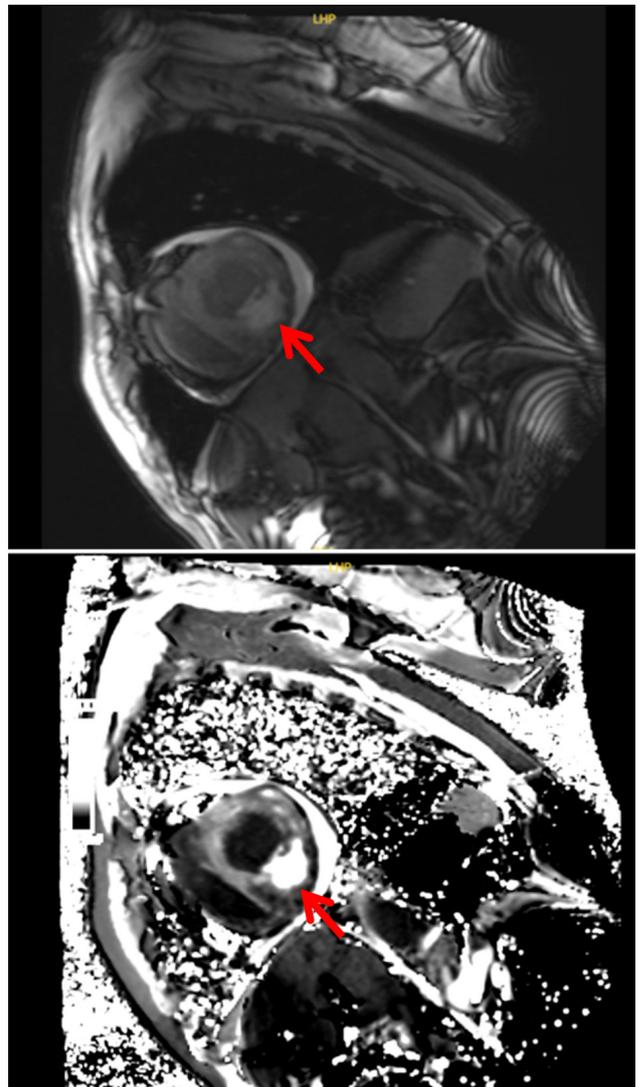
Magnetic resonance imaging showing myocardial metastasis. The upper image demonstrates tumor and pericardial effusion on T2-weighted imaging, while the lower image shows apparent diffusion coefficient mapping. The red arrows indicate areas of focal myocardial thickening with diffuse abnormal signal intensity and contrast enhancement, suggestive of metastatic lesions.
